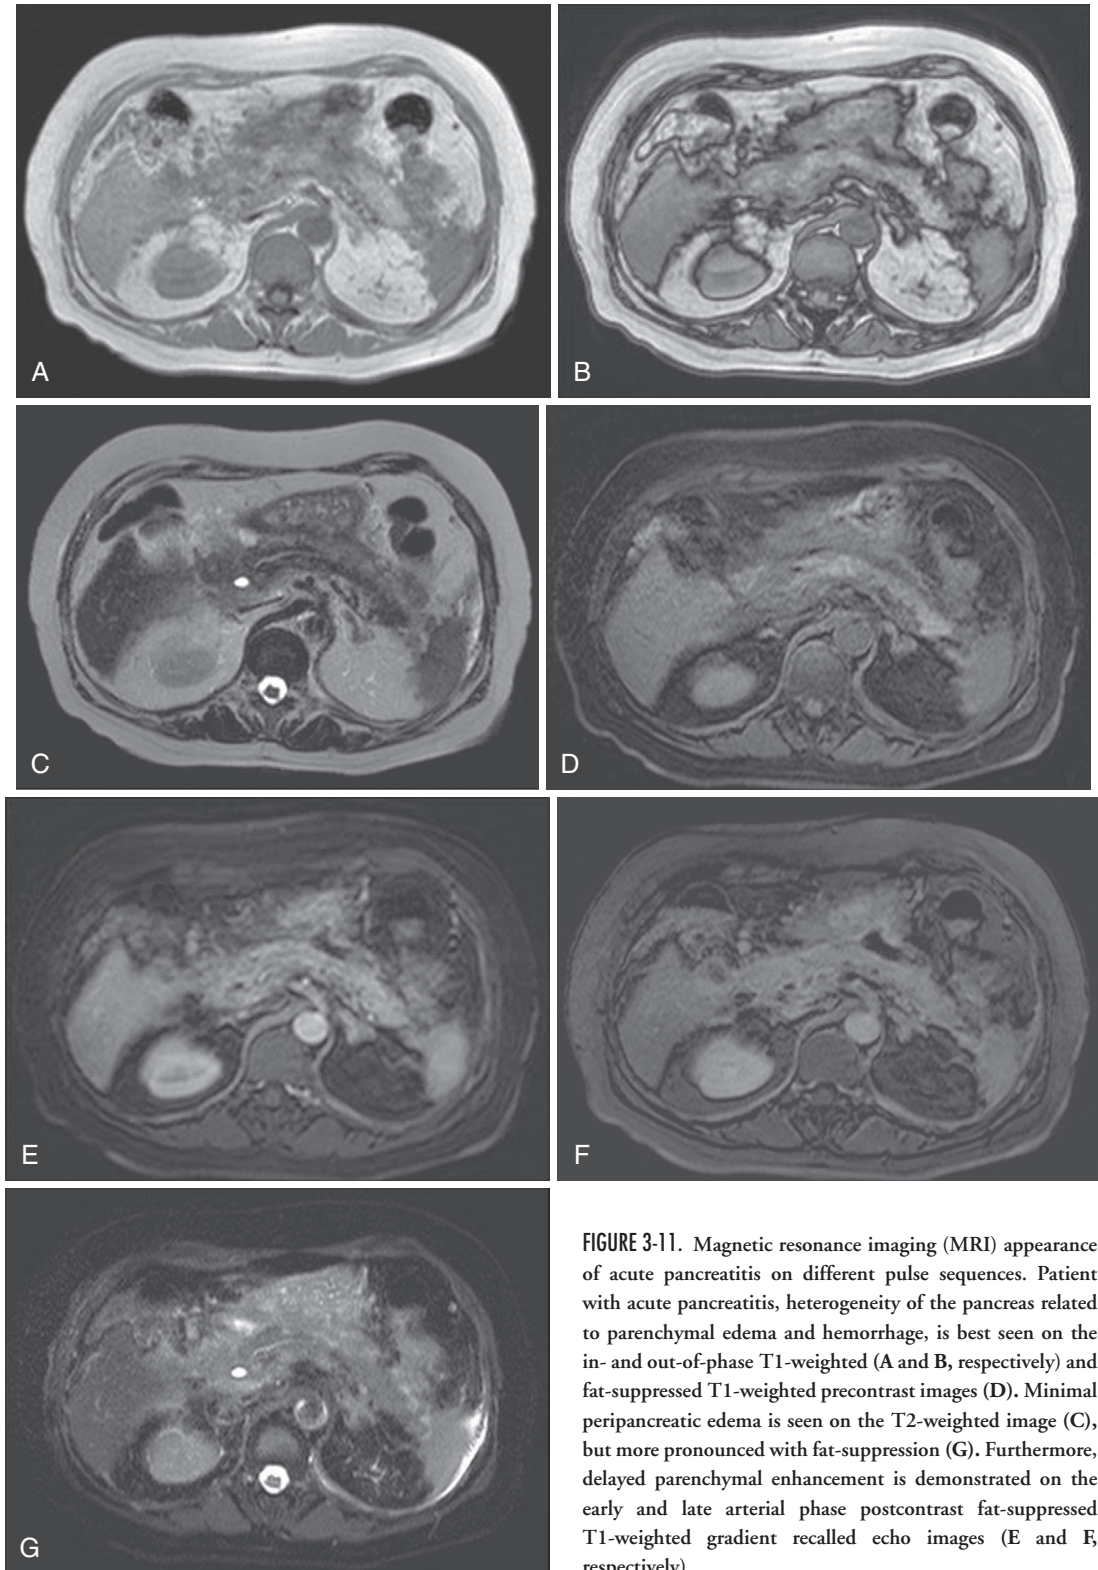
Magnetic resonance imaging (MRI) appearance of acute pancreatitis on different pulse sequences. Patient with acute pancreatitis, heterogeneity of the pancreas related to parenchymal edema and hemorrhage, is best seen on the in- and out-of-phase T1-weighted (A and B, respectively) and fat-suppressed T1-weighted precontrast images (D). Minimal peripancreatic edema is seen on the T2-weighted image (C), but more pronounced with fat-suppression (G). Furthermore, delayed parenchymal enhancement is demonstrated on the early and late arterial phase postcontrast fat-suppressed T1-weighted gradient recalled echo images (E and F, respectively).
